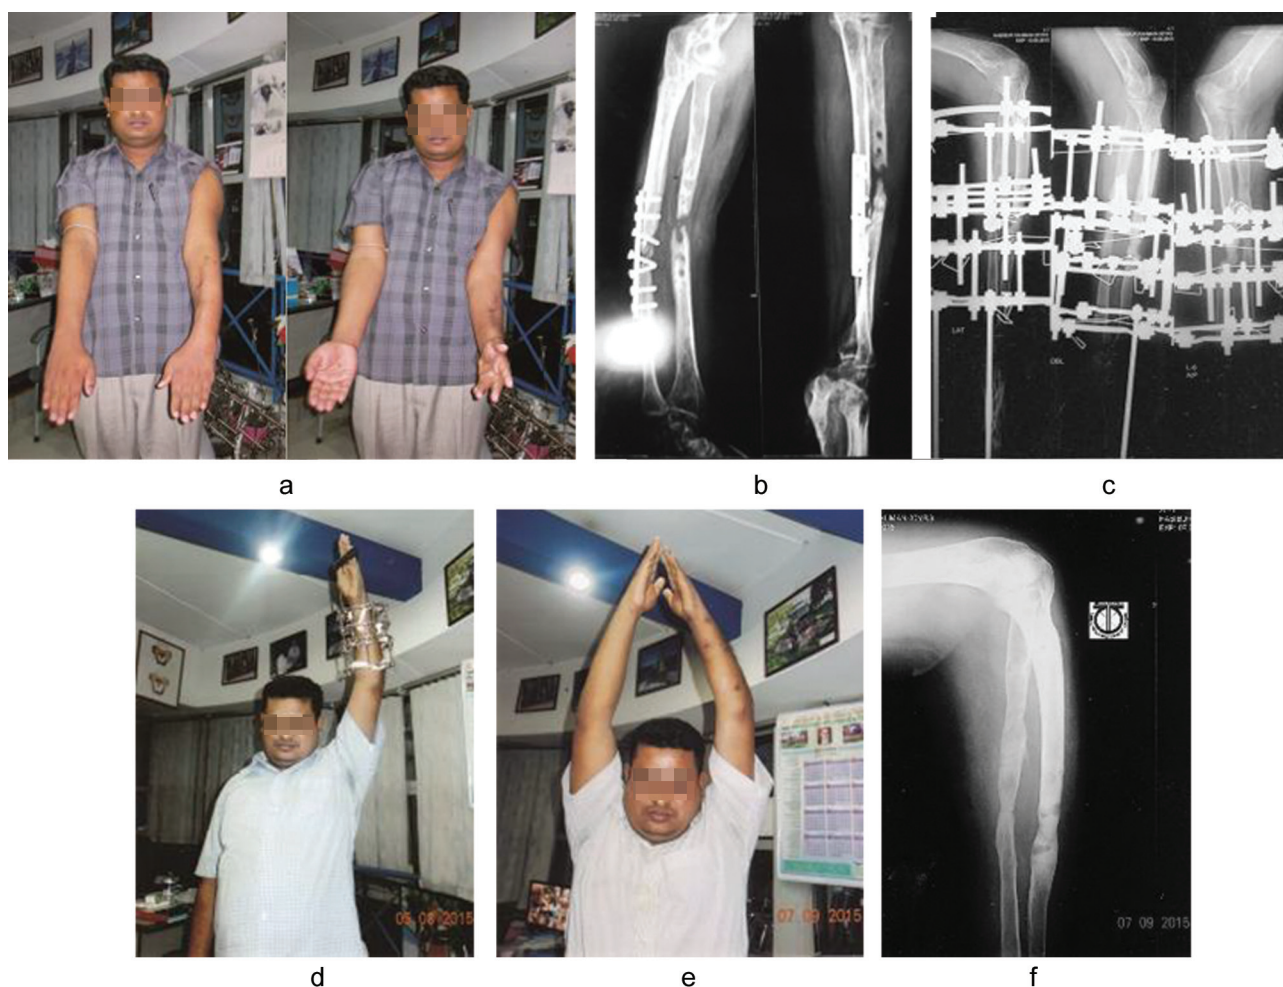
a – deformed left forearm before surgery; b – non-union of the left ulna with implant failure, atrophic gap non-union, left radius; c – during treatment with the Ilizarov apparatus; d – the Ilizarov apparatus on the left forearm; e – full function with straight left forearm; f – final radiograph after 7 months; excellent union
